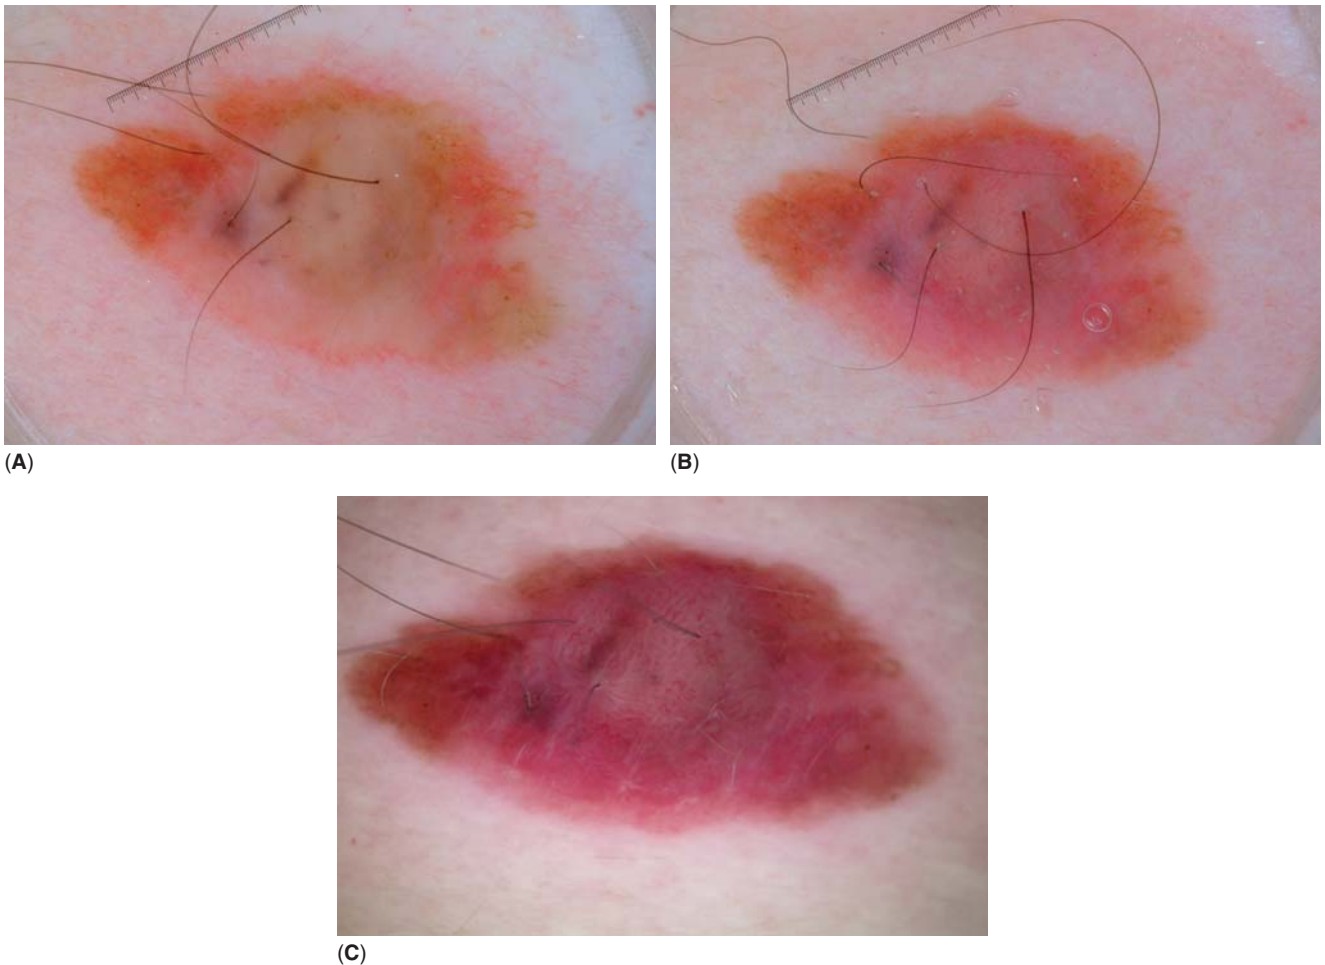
The three images are of the same melanoma 1.65 mm in thickness arising in a pre-existing nevus. Image (A) was captured with an NPD using alcohol as the liquid interface. Image (B) was captured using NPD and ultrasound gel as the liquid interface. Image (C) is taken with PD without any direct contact with the skin. These images highlight the effects of placing pressure on the lesion. PD without direct skin contact (*image C*) allows for the blood vessels and vascular blush to be most apparent. Using gel as the liquid interface during NPD allows the operator to apply less pressure on the lesion as compared with NPD when alcohol is used as the fluid interface. As can be seen in the figure, minimizing the pressure being applied onto the skin during NPD examination (*image B*) will greatly enhance the ability to visualize the blood vessels. Besides the effects of pressure, this case also highlights some of the inherent difference between nonpolarized and polarized light. Notice that chrysalis/crystalline structure can be seen in the PD image (*bottom*) but is not apparent in the two NPD images. *Abbreviations:* PD, polarized dermoscopy; NPD, nonpolarized dermoscopy.
